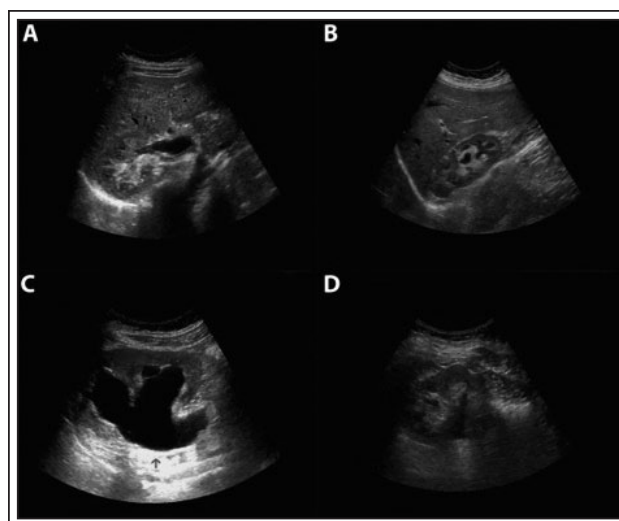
Ultrasound images of kidneys demonstrating improvement in hydronephrosis after surgery. Images A and C are right and left kidneys respectively preoperatively. Image B and D are postoperative right and left kidneys respectively.
